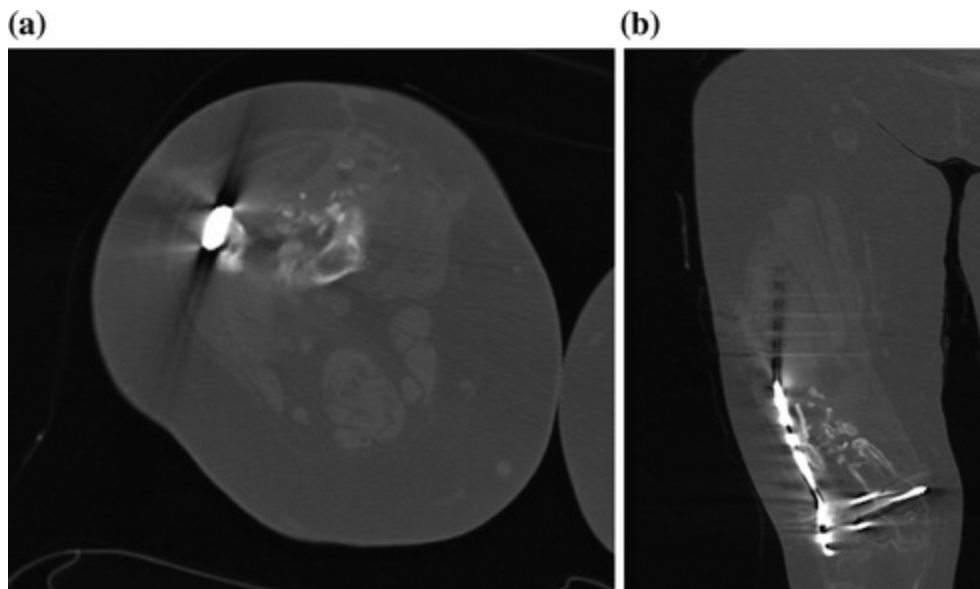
Computed tomography scan images showing the lack of bridging bone and obvious nonunion; a axial image; b coronal image
